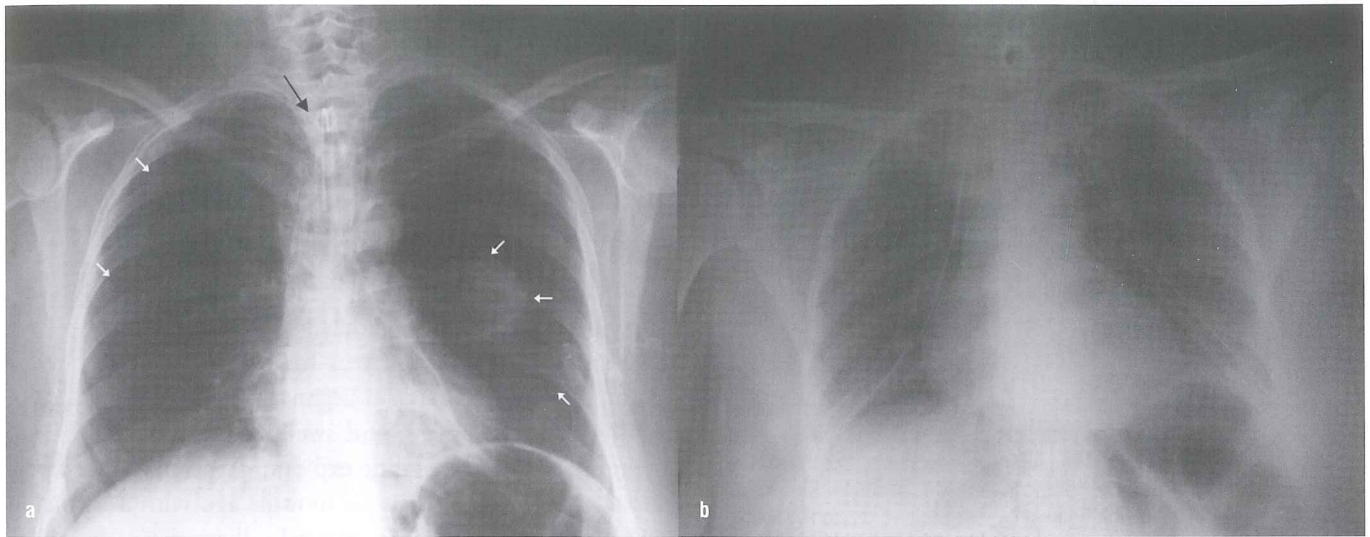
A) Chest X-ray shows the tracheostomy cannula and bilateral pneumothoraces. B) Chest X-ray taken after the application of bilateral tube thoracostomy.
